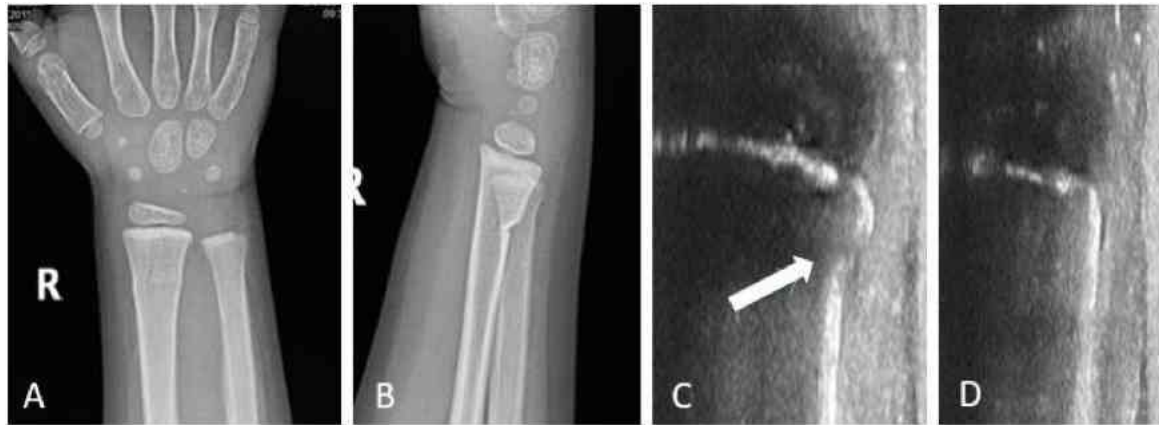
Ultrasound and X-ray pictures of distal forearm torus fracture
